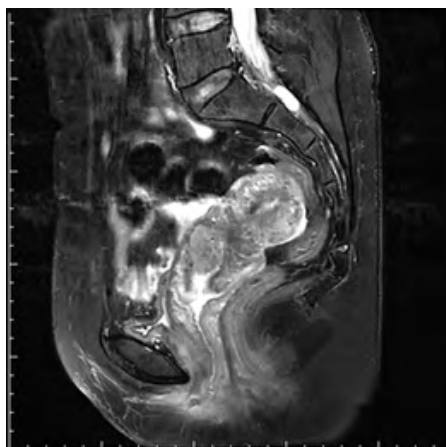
MRI (sagittal T2WI): Mixed signal shadow of the anterior wall of the cervical canal
